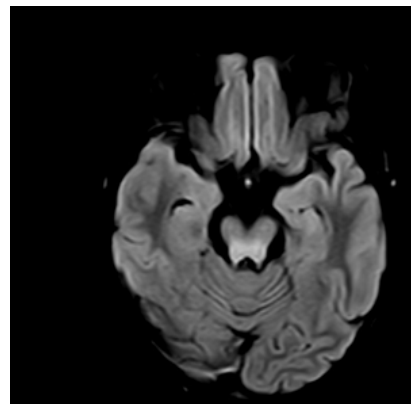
MRI showing, Axial FLAIR at the level of the midbrain - hyperintensity in the tegmentum with preserved red nuclei and substantia nigra, consistent with the classic “face of the giant panda sign.”
